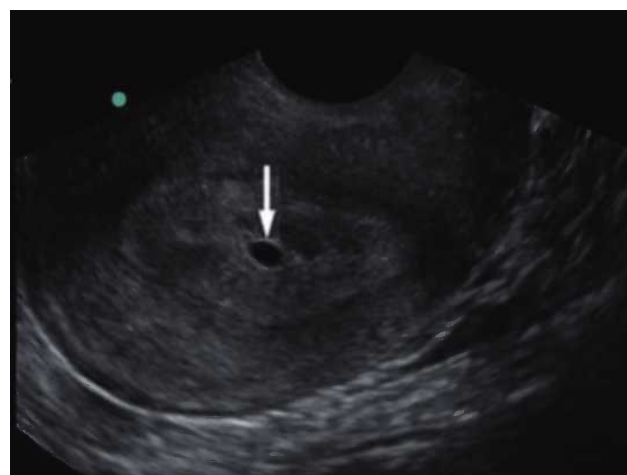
Gestational sac (arrow) seen on a sagittal view of the uterus on transvaginal ultrasound.
